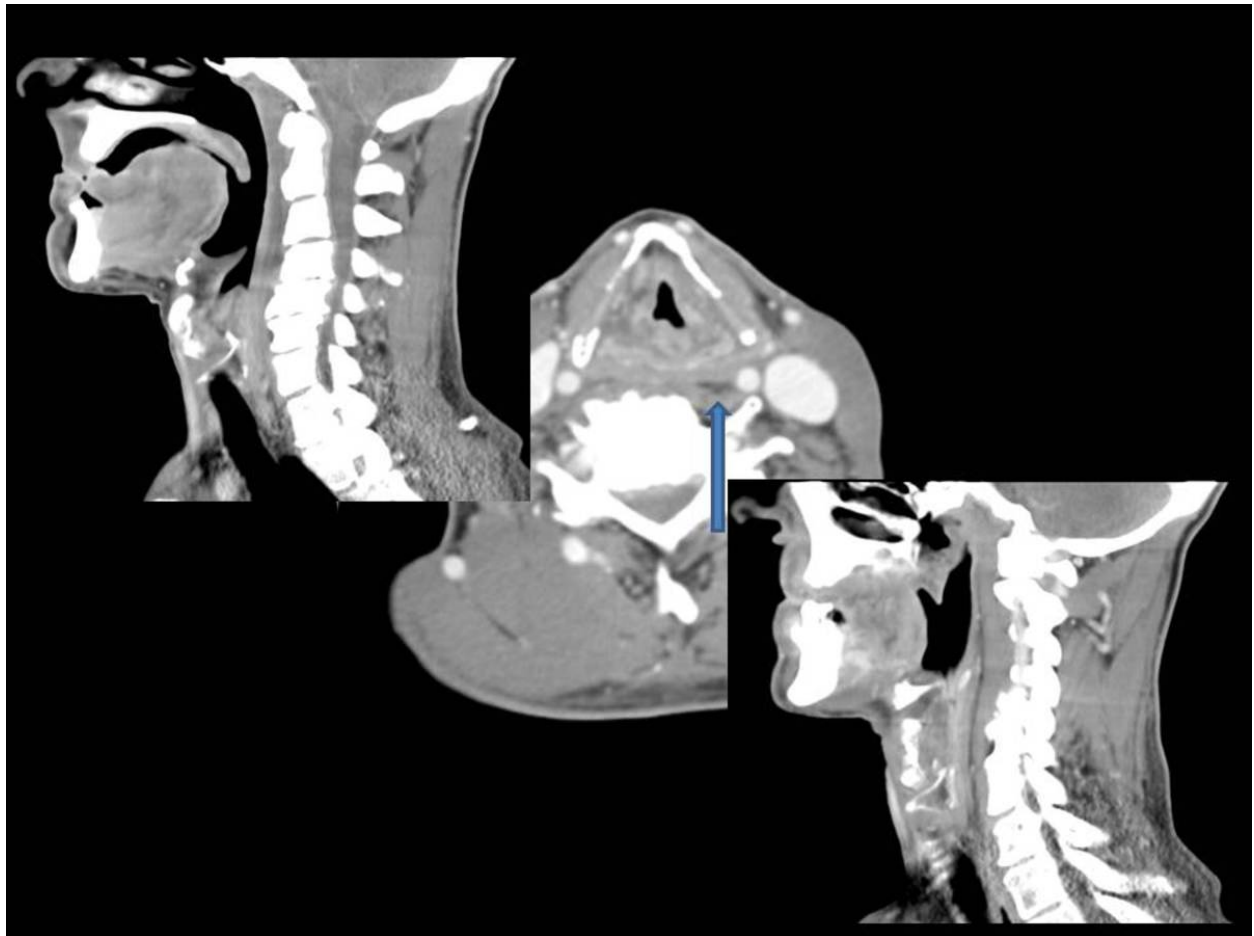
Tortuous internal carotid arteries. Unenhanced computed tomography - axial and sagittal views - demonstrates a retropharyngeal mass.
